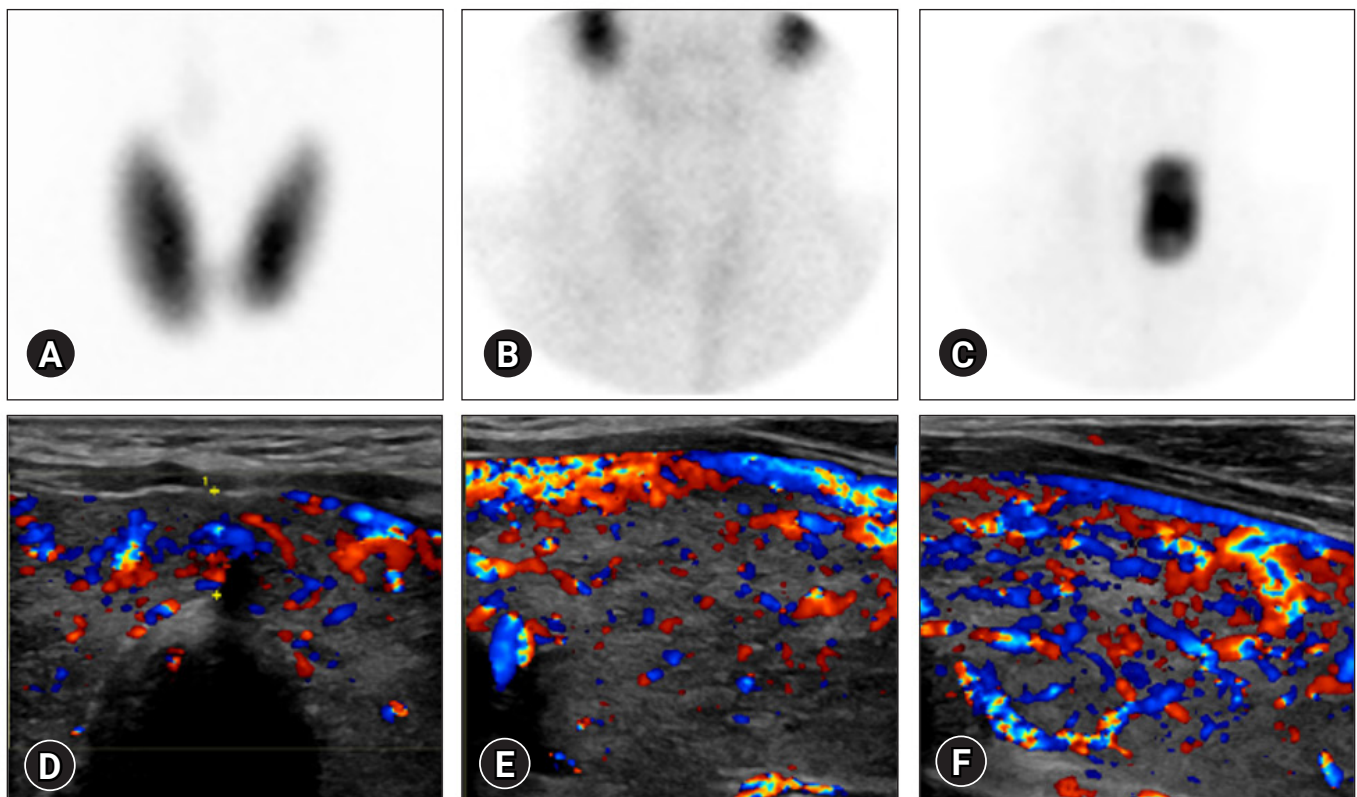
(A–C) Thyroid scans can assist in the differentiation of patients with thyroid diseases. Typical appearances of ^{99m}Tc pertechnetate scans are shown in (A) Graves disease, (B) thyroiditis, and (C) toxic nodular goiter. (D–F) Doppler ultrasonography views of Graves disease show a classic finding of increased blood flow in a 28-year-old man. (D) Transverse view of isthmus area and longitudinal views of the (E) right lobe and (F) left lobe of the thyroid gland.
